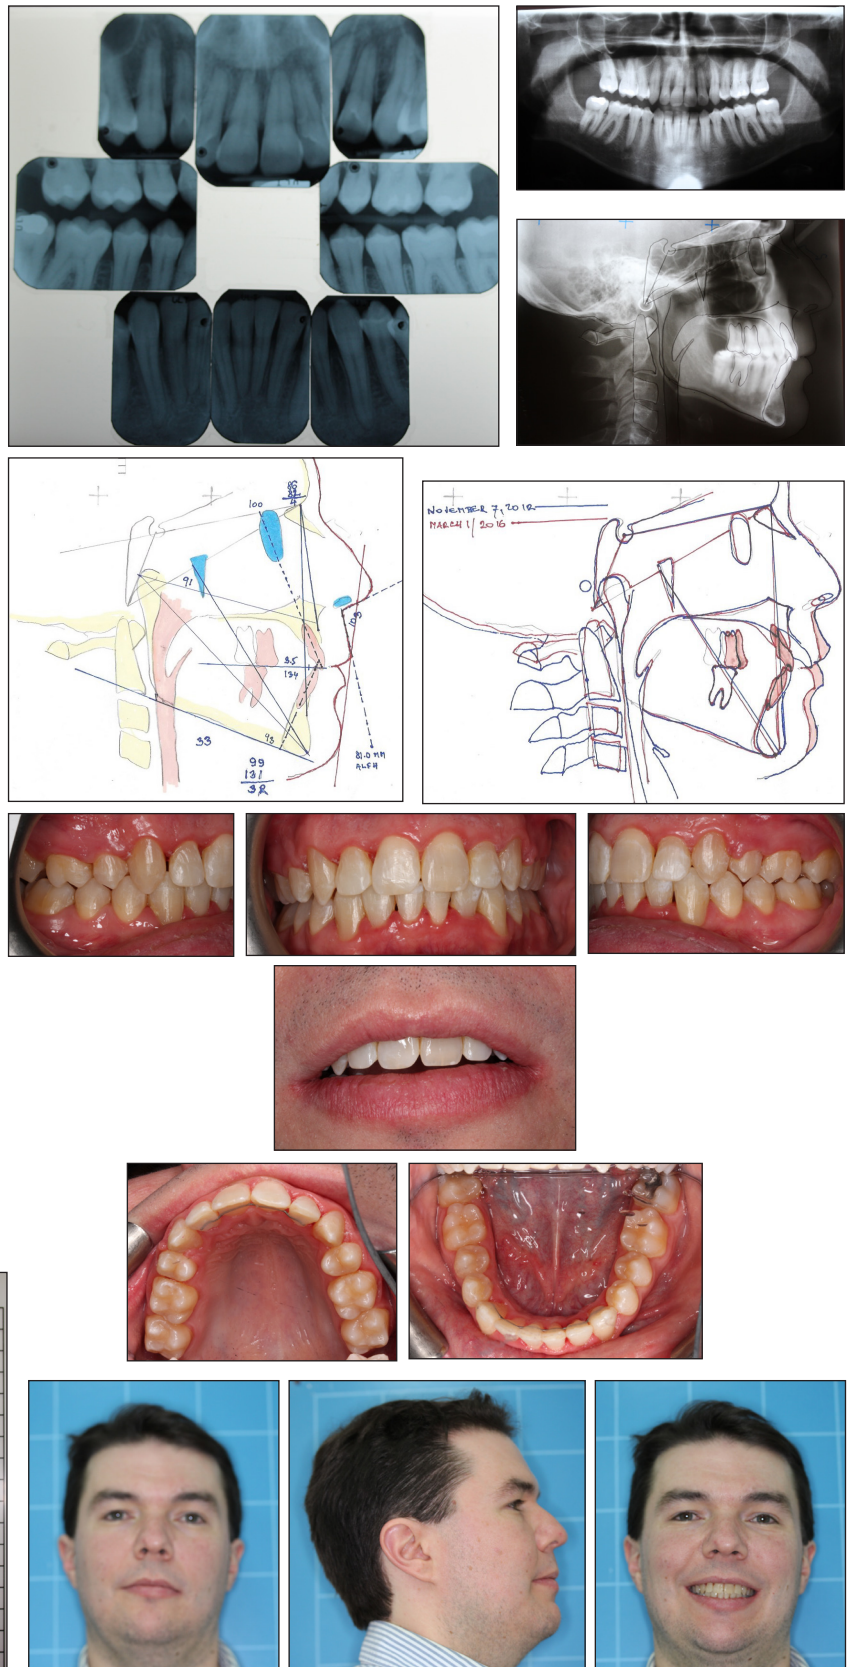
A) Post-treatment PA radiograms and bite wings; B) Post-treatment panoramic radiogram; C) Post-treatment lateral cephalometric radiogram; D) Post-treatment cephalometric tracing; E) Pre- and post-treatment cephalometric superimposition on Sella – Nasion; F) Post-treatment, right lateral view; G) Post-treatment, frontal view; H) Post-treatment, left lateral view; I) Post-treatment, lips reposed; J) Post-treatment, maxilla, occlusal view; K) Post-treatment, mandible, occlusal view; L) Post-treatment, posture, frontal view; M) Post-treatment, posture, lateral view; N) Post-treatment, frontal view; O) Post-treatment, lateral view; P) Post-treatment, posed smile
